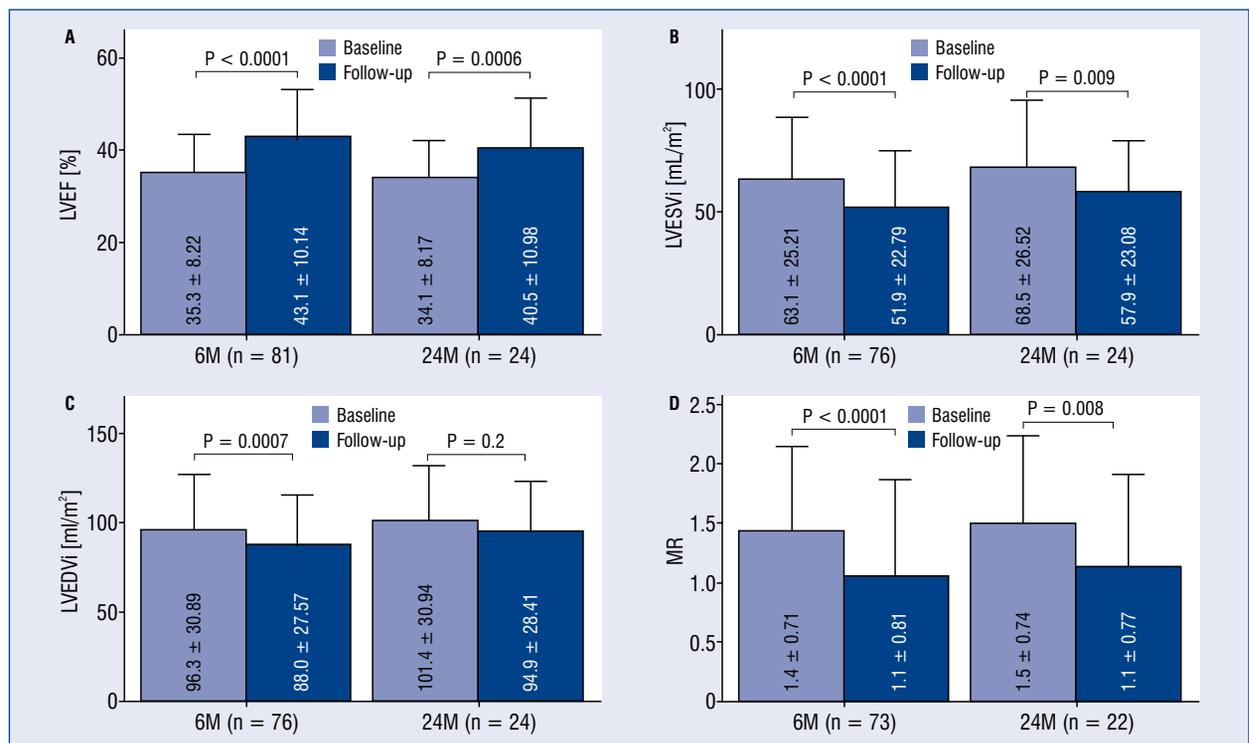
Echocardiographic measurements at baseline (light blue) and during follow-up (dark blue). A. Left ventricular ejection fraction (LVEF); B. Left ventricular end-systolic volume indexed to body surface area (LVESVi); C. Left ventricular end-diastolic volume indexed to body surface area (LVEDVi); D. Mitral regurgitation (MR). Mean value ± standard deviation was placed in the bar with a p-value to compare baseline and follow-up values; N — number of patients; 6M — 6 months; 24M — 24 months.
